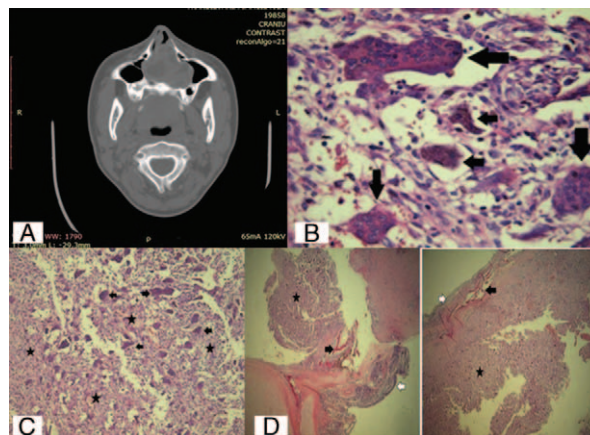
A, Computed tomography scan (axial views) showing the tumor occupying both nasal cavities and extending into the maxillary sinuses. B, The tumor is composed of a mixture mononuclear round to oval stromal cells with mitoses and no hyperchromatism (black star) and numerous giant cells (black arrows) ($\times 100$, HE). C, Giant cells (black arrow) contain between 10 and 60 nuclei with morphology similar to the nuclei of stromal cells ($\times 400$, HE). D, Tumor (black star) infiltrates the bone (black arrow) underneath the mucosa (white arrow) ($\times 25$, HE).
